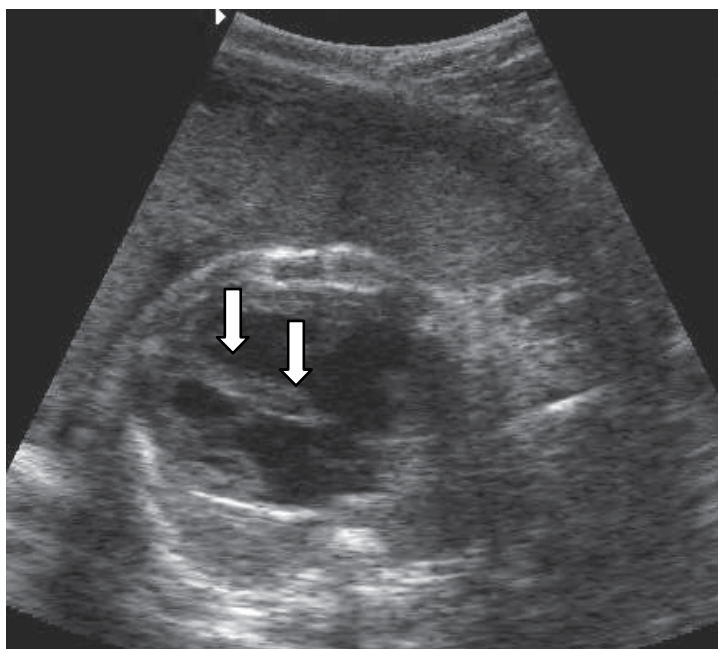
Image of fetal ultrasonography: hypertrophic cardiomyopathy associated with Diabetes Mellitus
